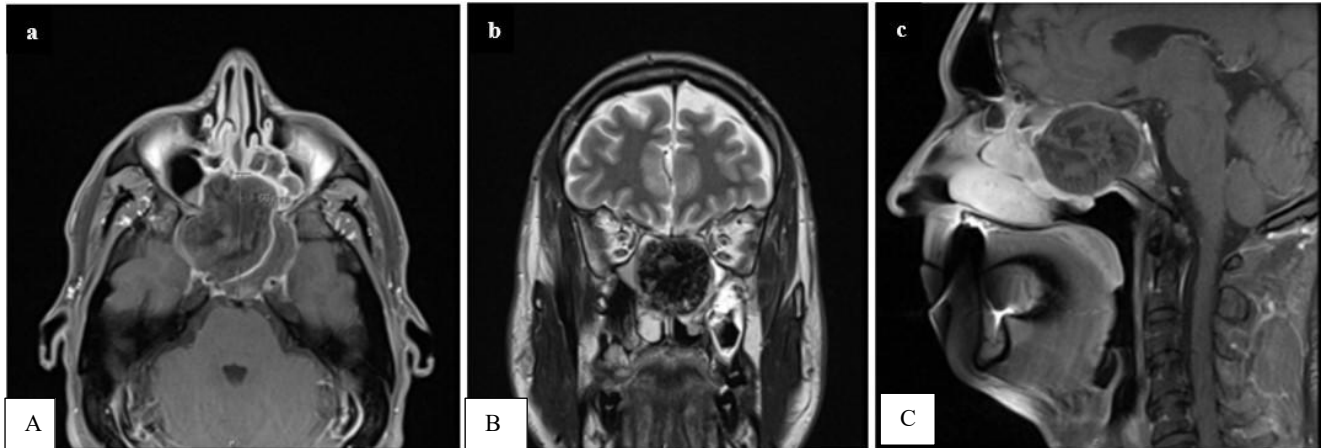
Preoperative magnetic resonance imaging with contrast revealing a space-occupying lesion in the sphenoid sinus, with central T1/T2 signal void and peripheral contrast enhancement: (A) axial plane, (B) coronal plane and (C) sagittal plane.
